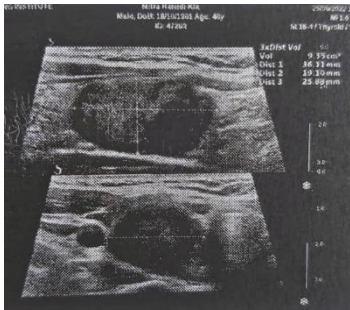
Ultrasonography of thyroid nodule three months after RFA. Thyroid ultrasonography indicated a significant decrease in volume: 36×19×25mm (9.3 mL), without lymphadenopathy.
